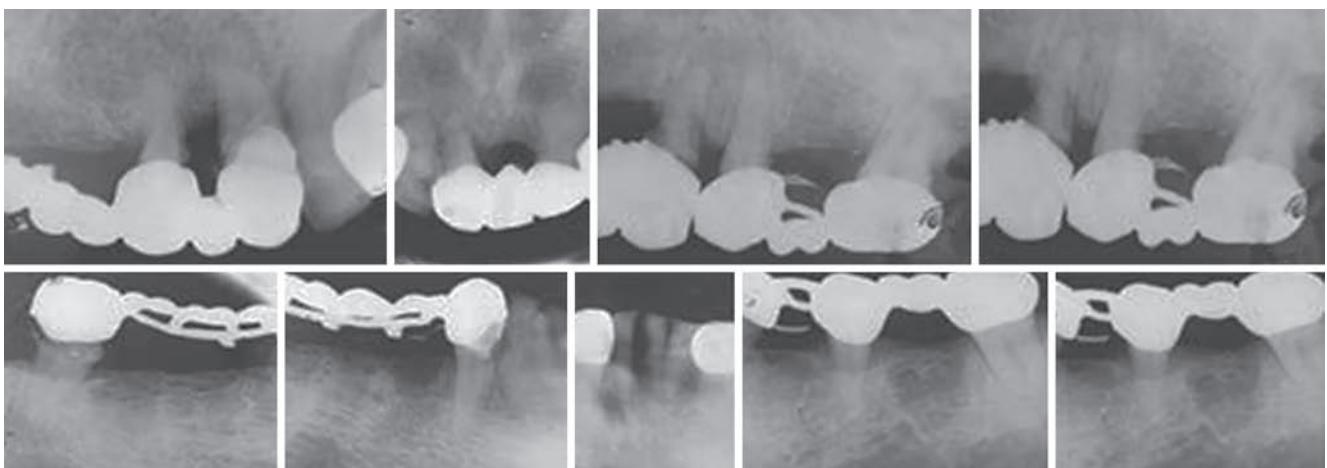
Preoperative periapical radiographs
